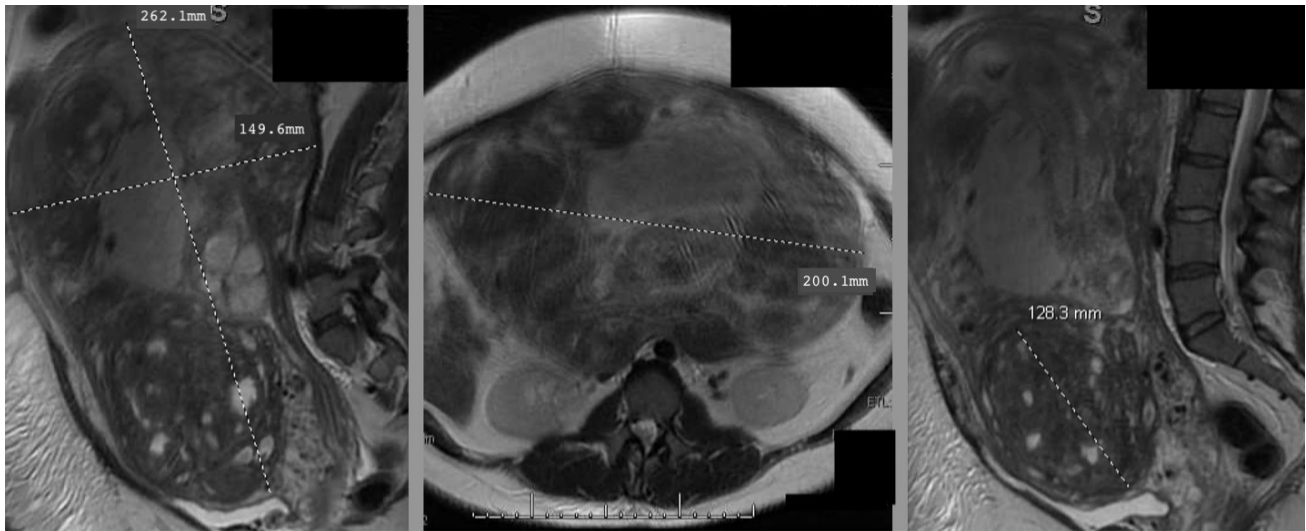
MRI of Fibroid Uterus
